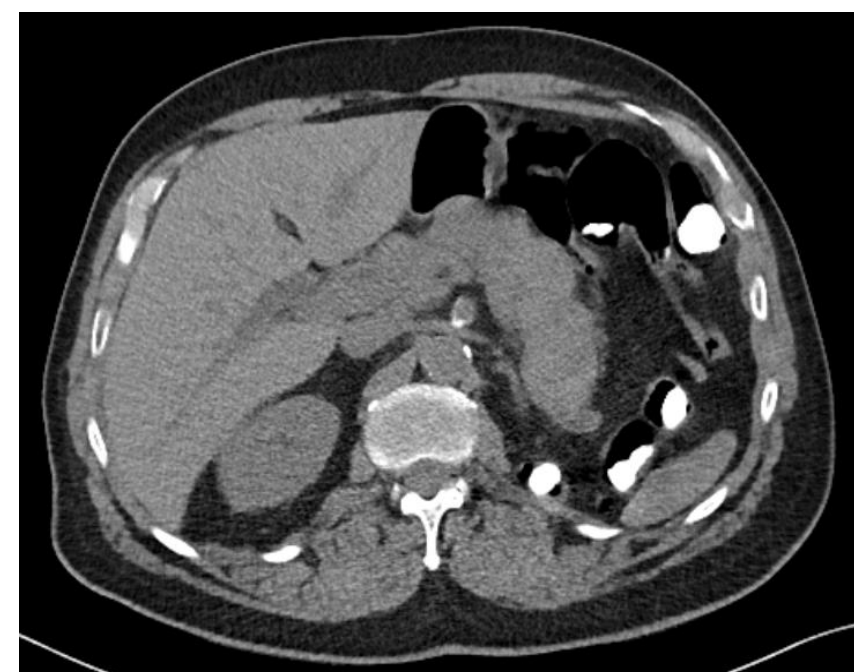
Abdominopelvic CT scan without contrast showing intrahepatic biliary ductal dilatation and a mass-like prominence of the pancreatic tail.
